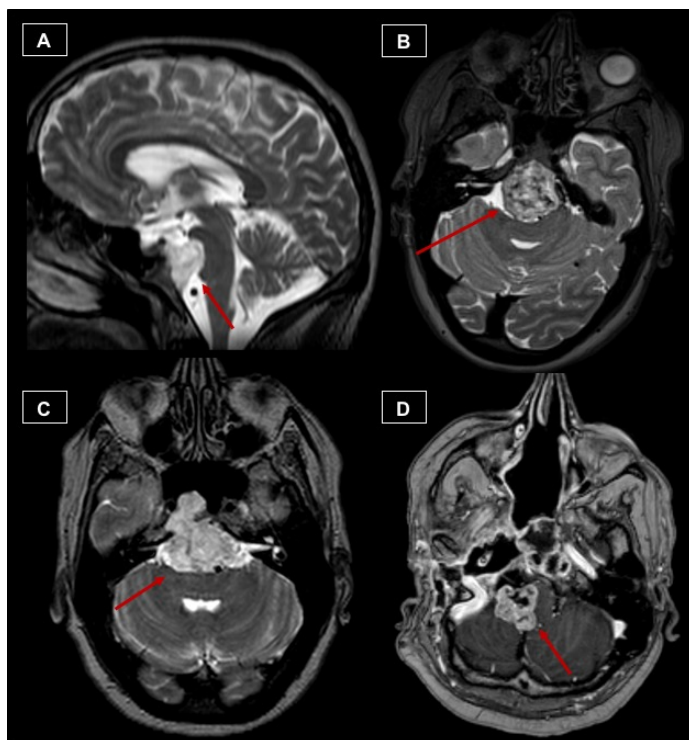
Sagittal T2-weighted (A), axial T2-weighted (B), axial T2-weighted (C) and axial T1-weighted post-contrast (D) MR images showing chordomas (red arrows) extending into the antero-lateral cistern of the brainstem.
